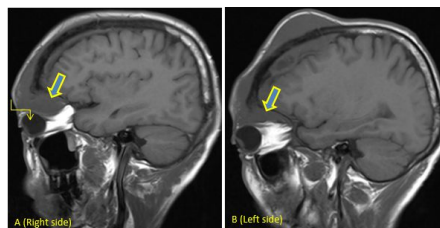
Pre-contrast MRI Brain.
